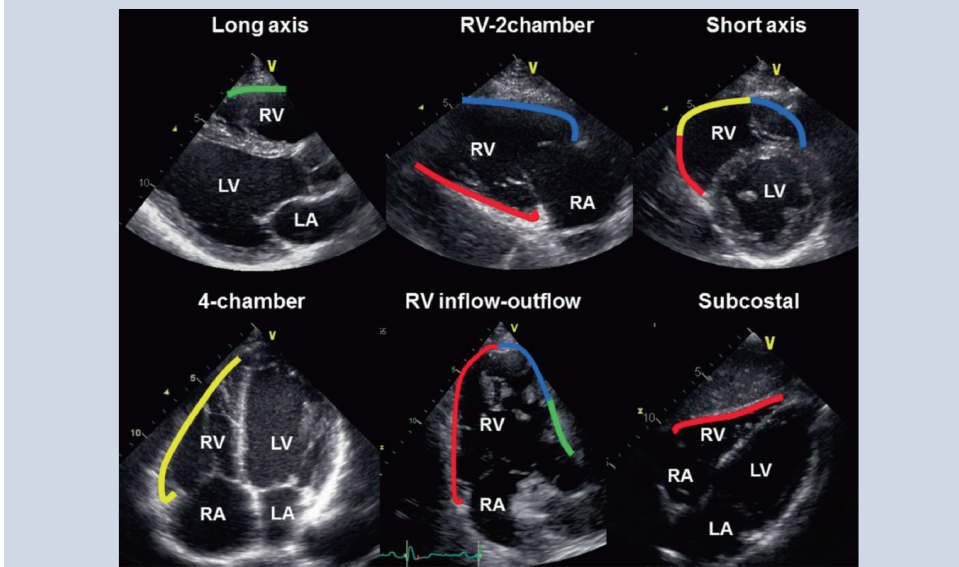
Echocardiographic arrhythmogenic right ventricular dysplasia/cardiomyopathy (ARVD/C) protocol and right ventricular (RV) view
